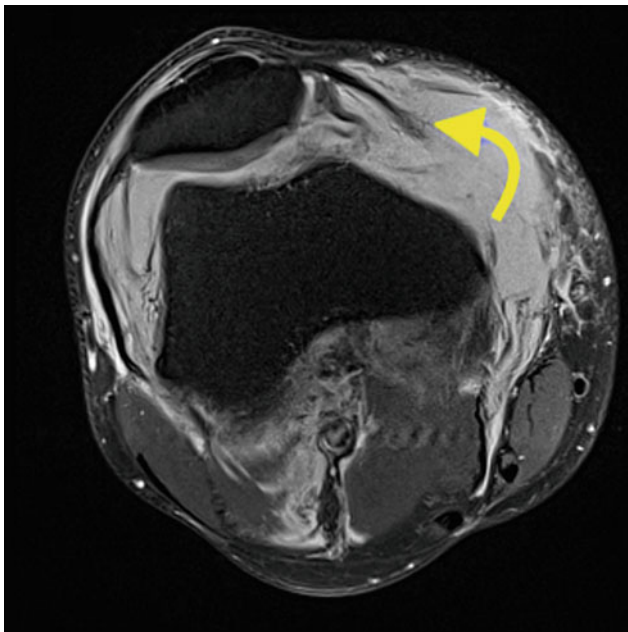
Axial MRI image demonstrating avulsion of the MPFL off the medial femoral condyle (yellow arrow)
